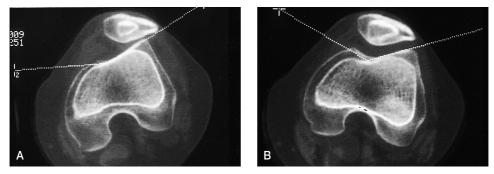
An 18-year-old woman, who was referred because of anterior knee pain and patellar instability of her left knee. She had recurrent hemarthroses and severe giving-way with falling to the ground during activities of daily living. CT shows the patella lateralized at 0°—PFM type 1—(A), and relocated in the femoral trochlea at 30° (B) (reproduced with permission from Sanchis-Alfonso et al. 1994).
